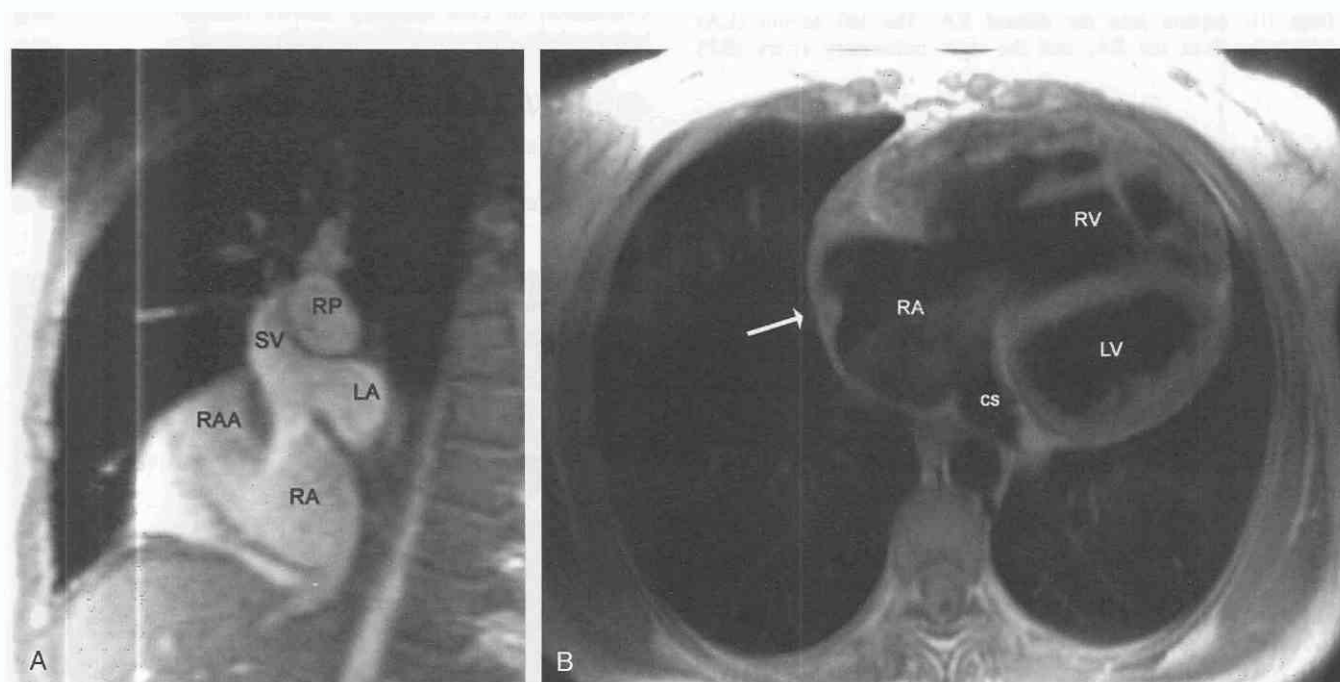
MR image obtained from a 28-year-old woman with sinus venosus atrial septal defect. *A*, Right parasagittal gradient-echo acquisition through the entrance of the superior vena cava (SV) into the right atrium (RA). The defect results in continuity among the lower SV, the left atrium (LA), and the right atrium. RAA, right atrial appendage; RP, right pulmonary artery. *B*, Axial spin-echo acquisition through the right atrium (RA) and right ventricle (RV). The right atrium, right ventricle, and coronary sinus (CS) are each dilated, and the heart is rotated into the left chest. The interventricular septum is flat, and RV myocardial trabeculae in this patient are more prominent than in the patient in Figure 33–67*B*. Note the high-signal-intensity crista terminalis (*arrow*) along the lateral aspect of the RA wall. LV, left ventricle.
